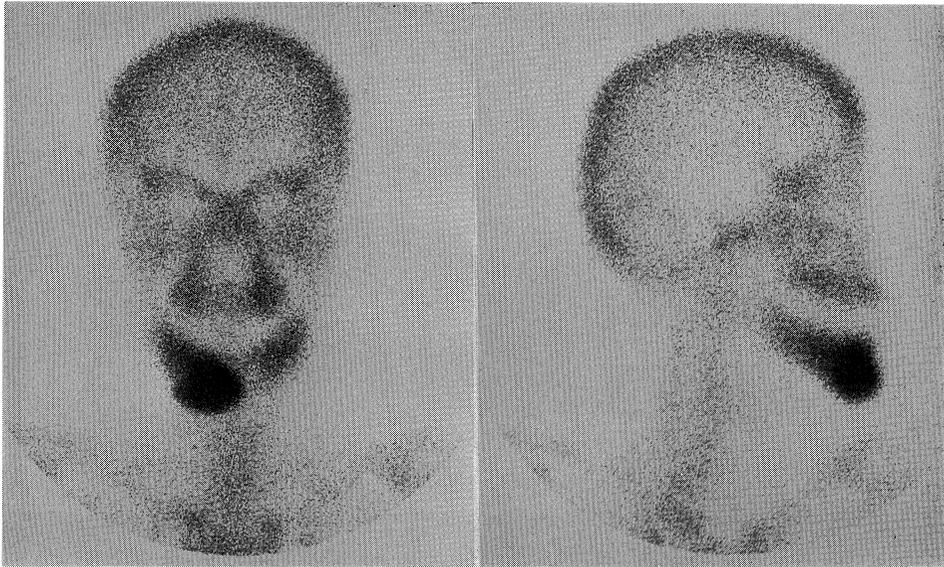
Bone scintigram (Anteroposterior and right lateral view).
